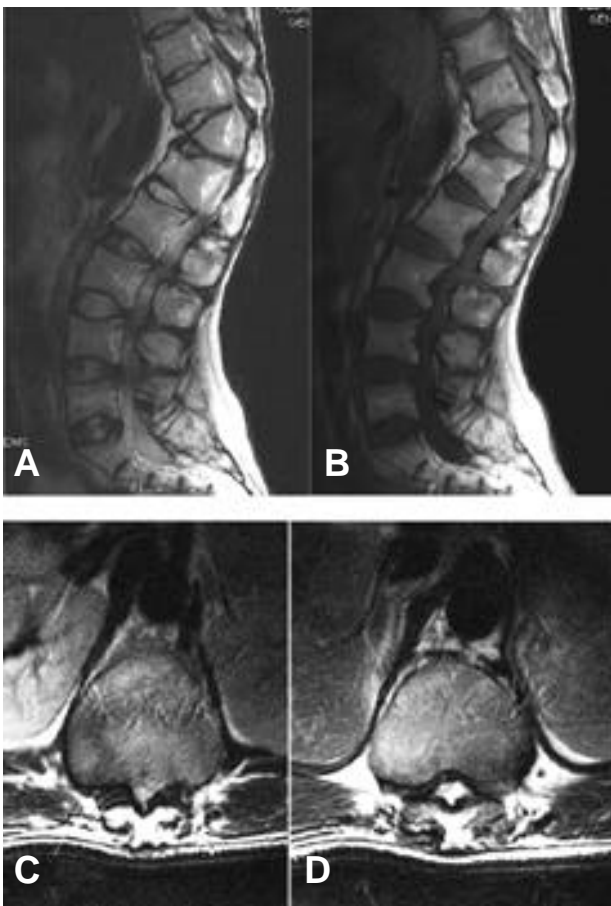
Preoperative MRI (A) T1 Sagittal image, (B) T2 Sagittal image, (C) T2 Axial image(T 11- T12 disc level), (D) T2 Axial image(T12- L1 disc level) There is central spinal stenosis at the level of T11/12, T12/L1 and central spinal stenosis, with bulging disc at the level of L2/3, L3/4, L4/5. The shape of T12 vertebral body is wedge form and short pedicles with bilateral neural foraminal narrowing coexist at lumbar and lower thoracic spines.
